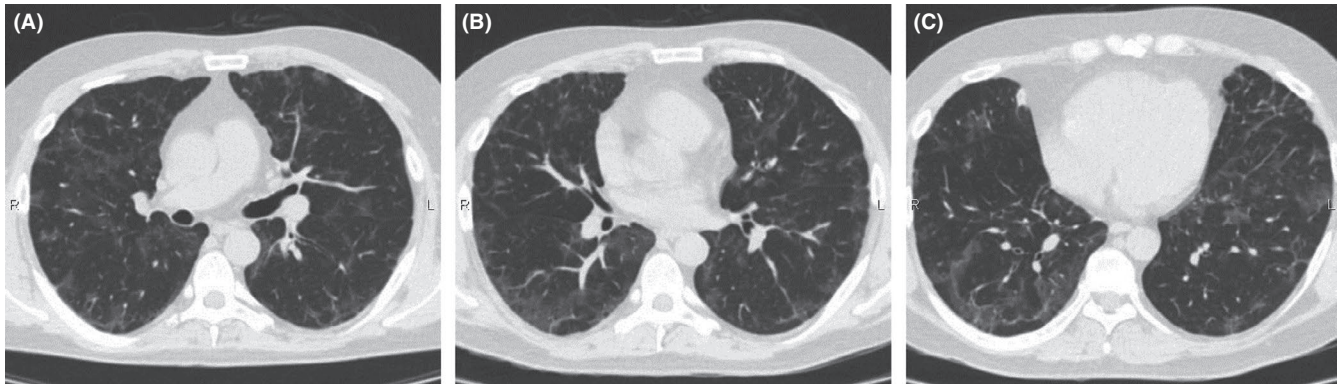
The CT scans show the GGO, with the formation of gentle fibrous tissue
